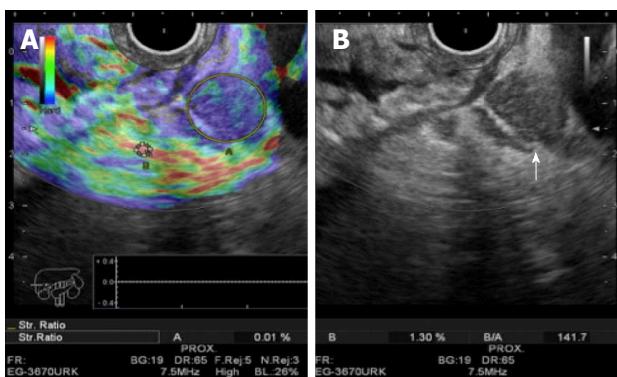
A lymph node being evaluated by elastography, for a gastric tumor staging. A: Qualitative elastography (color tones red-green-blue) shows the lesion with a blue-predominant color tone, which represents a hard tissue and suggest malignancy. The Strain Ratio (quantitative elastography) is being calculated by comparing two different areas (A and B). Area A includes as much of the target lesion as possible. Area B is selected within a soft (red) reference area outside the target lesion. The result (B/A = 141.7) suggests malignancy; B: Shows the round, sharply demarcated and hypoechoic lymph node (white arrow). The endoscopic ultrasound-elastography was done using a Hitachi-Avius console with a radial scope EG-3630URK (from Pentax Medical).
